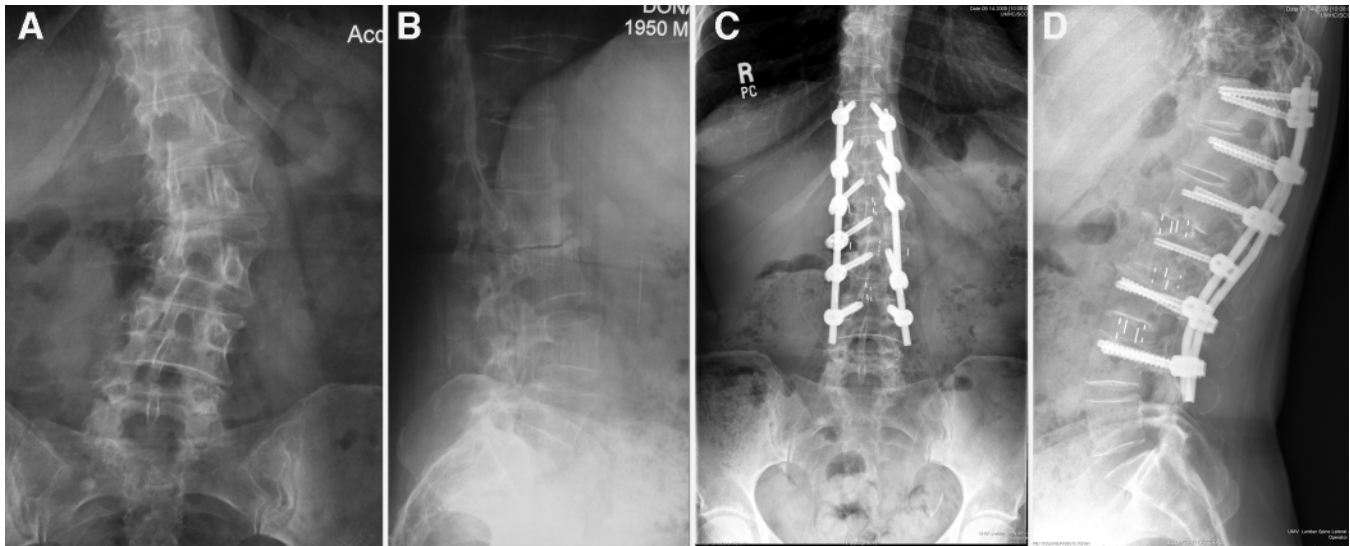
Case 19. Radiographic examples of lumbar degenerative scoliosis treated via an anterior-posterior minimally invasive approach. A and B: Preoperative images demonstrating a 32° Cobb angle. C and D: Postoperative images demonstrating curve correction to 5° with maintenance of proper local sagittal balance.
